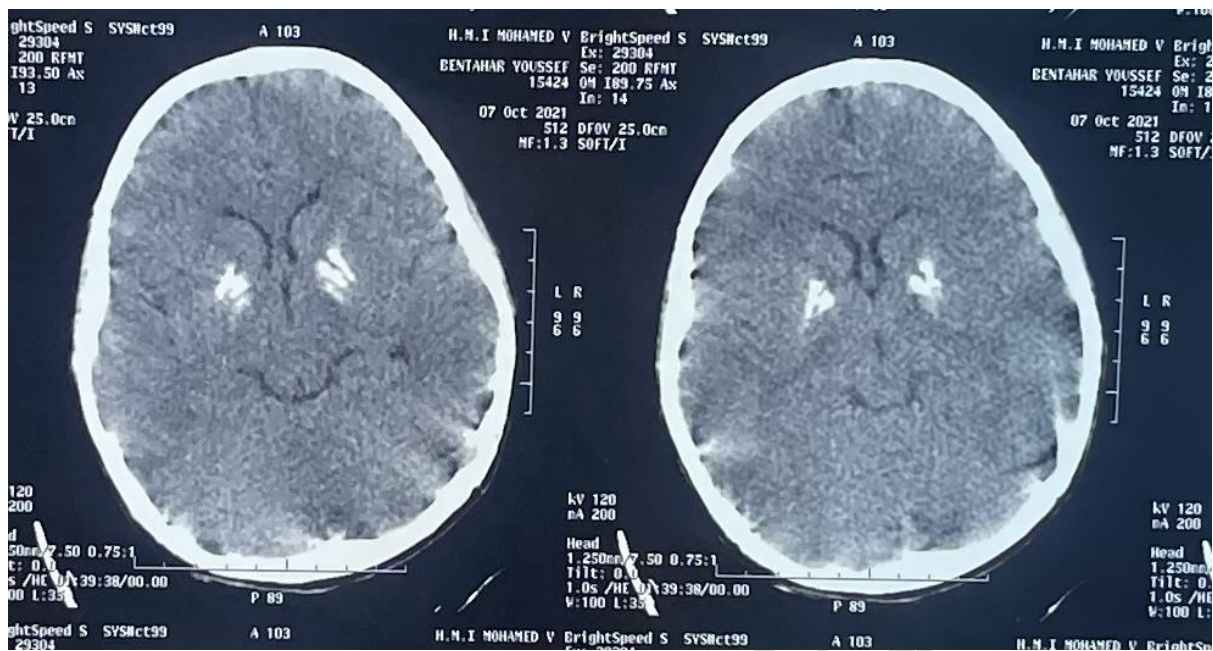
A brain CT scan showing calcifications of the basal ganglia in our patient.
